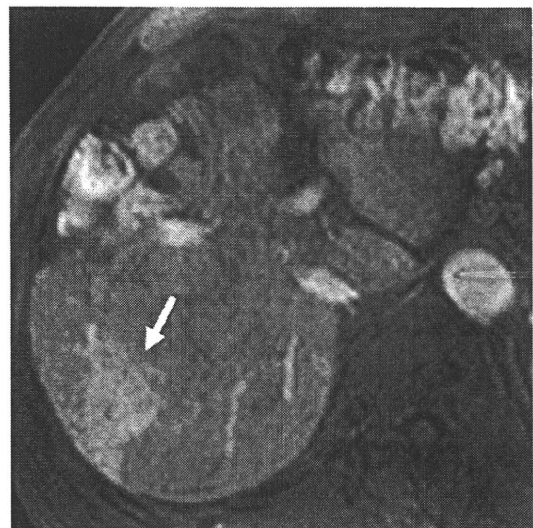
Arterial-phase contrast-enhanced dynamic MR image shows increased enhancement of liver parenchyma (arrow), presenting early patchy enhancement.
